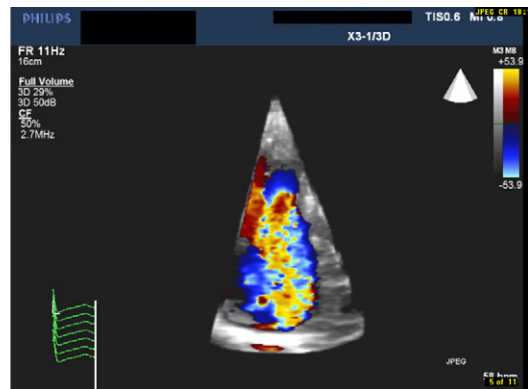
Parasternal long axis view. (A) In this patient status post endocarditis of the tricuspid valve. It was clear from 2D imaging that there was lack of coaptation between two of the tricuspid valve leaflets. Which two leaflets failed to coapt was much less clear. The view that the authors obtained from the parasternal long axis view showed unequivocally that the septal leaflet was normal, and it was lack of coaptation between the anterior and posterior leaflets that resulted in the severe tricuspid regurgitation. (B) The severe tricuspid regurgitation 3D color jet (case 6).
